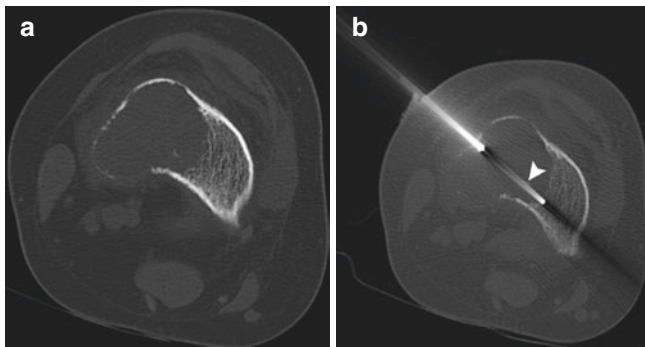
(a) CT-guided bone biopsy of a lytic lesion involving the distal femur (a). (b) The needle pathway was planned with the surgeon, and the needle route was imaged clearly to allow surgical resection of the needle pathway (*arrowhead*). Final diagnosis was giant cell tumor
